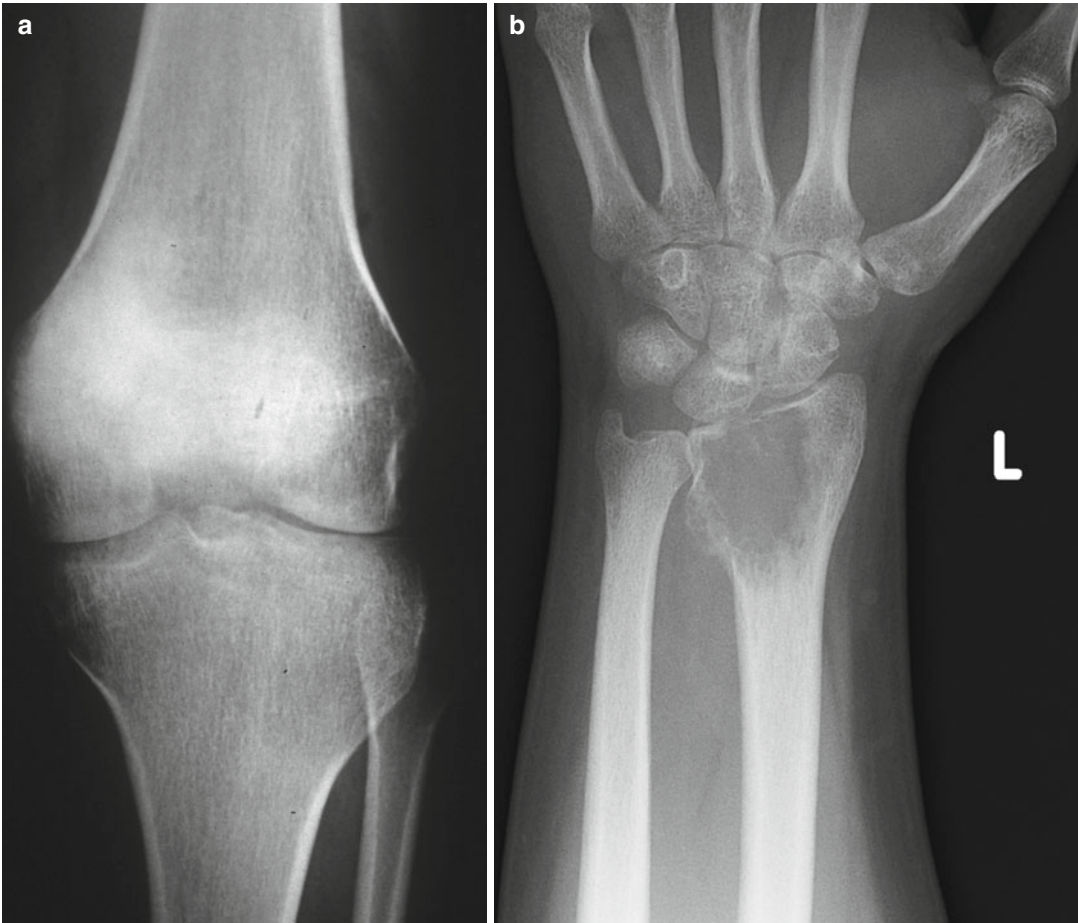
Plain radiographs showing (a) osteosarcoma of the distal femur with a blastic matrix, (b) giant cell tumour of the distal radius with a lytic matrix
